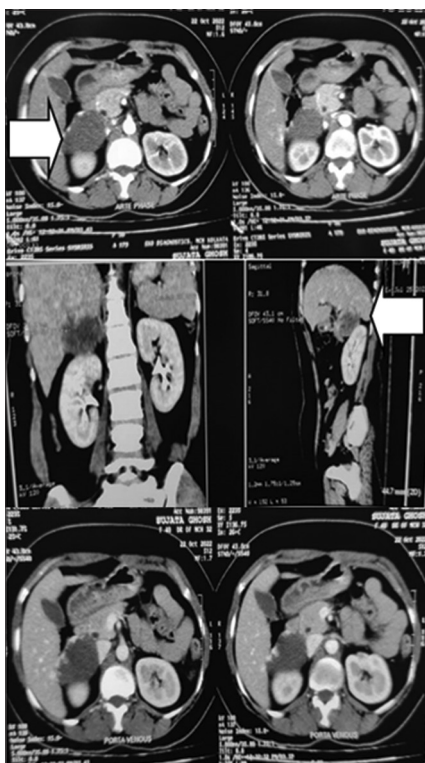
Triphasic computed tomography with adrenal protocol
